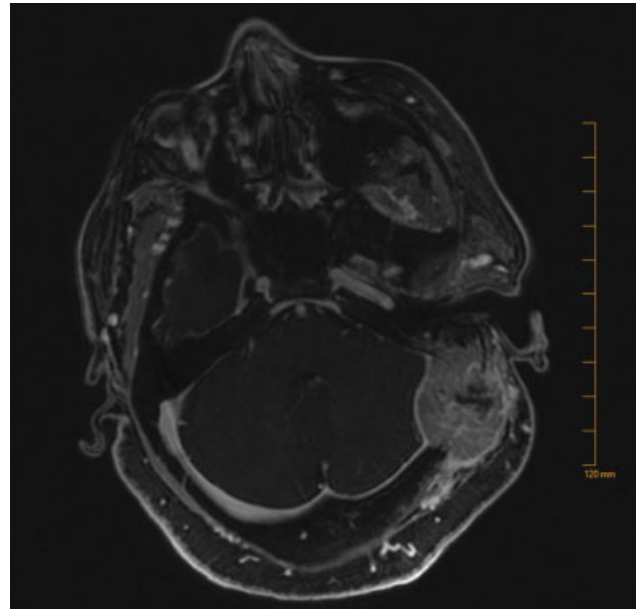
Preoperative axial magnetic resonance imaging demonstrating a giant left-sided extra-axial mass with bony destruction. The mass measured $6 \times 5 \times 4$ cm in dimension with displacement of the adjacent brain parenchyma.
